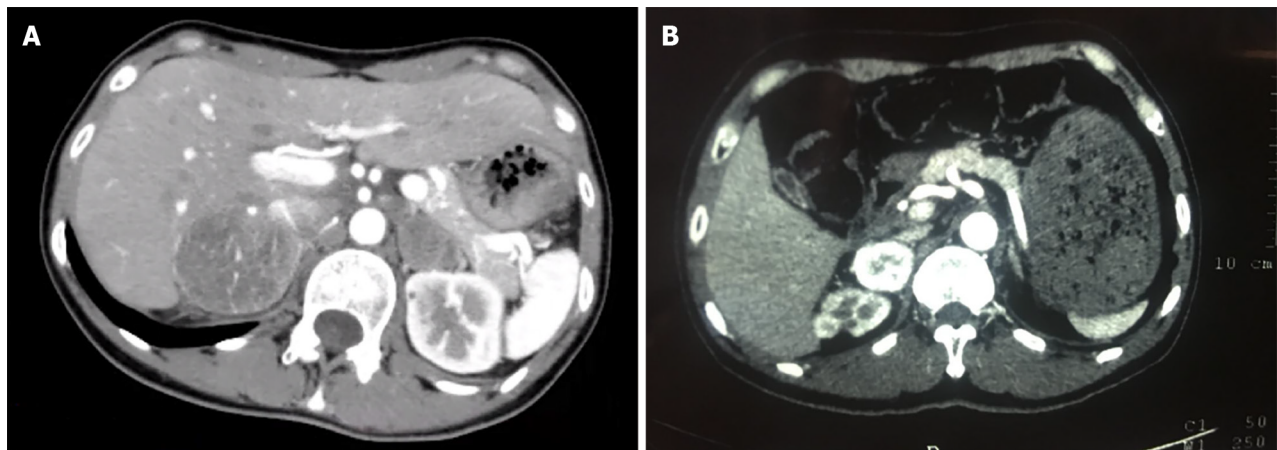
Bilateral adrenal computed tomography scans. A: Contrast-enhanced bilateral adrenal computed tomography scans of proband Ila. Space-occupying lesions of the bilateral adrenal masses were observed; B: Non-contrast enhanced + contrast-enhanced bilateral adrenal computed tomography scans of patient Ib.
